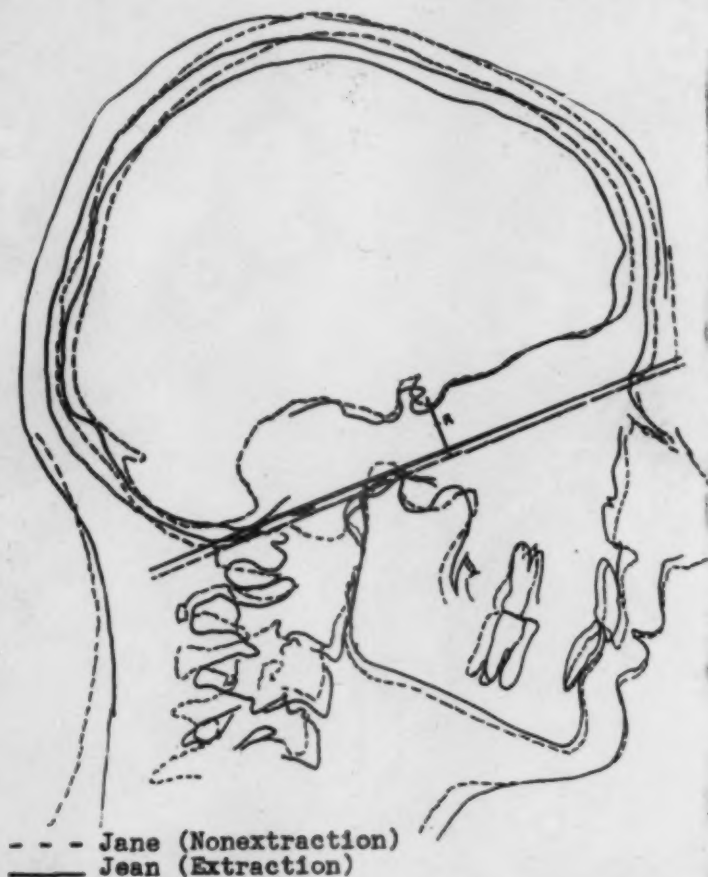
Superimposed tracings of Jean and Jane taken from lateral cephalometric x-rays.
